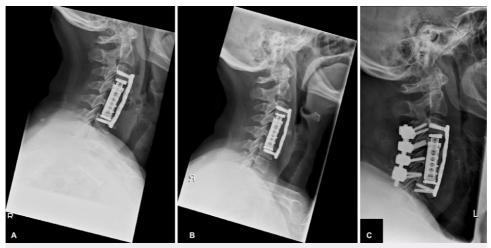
Postoperative images obtained in the 67-year-old patient. A: Radiograph obtained directly postresection and corpectomy. B: Radiograph with visible subsidence of the cage, obtained 4 weeks postoperatively. C: Radiograph obtained directly after revision of cage and instrumentation.
